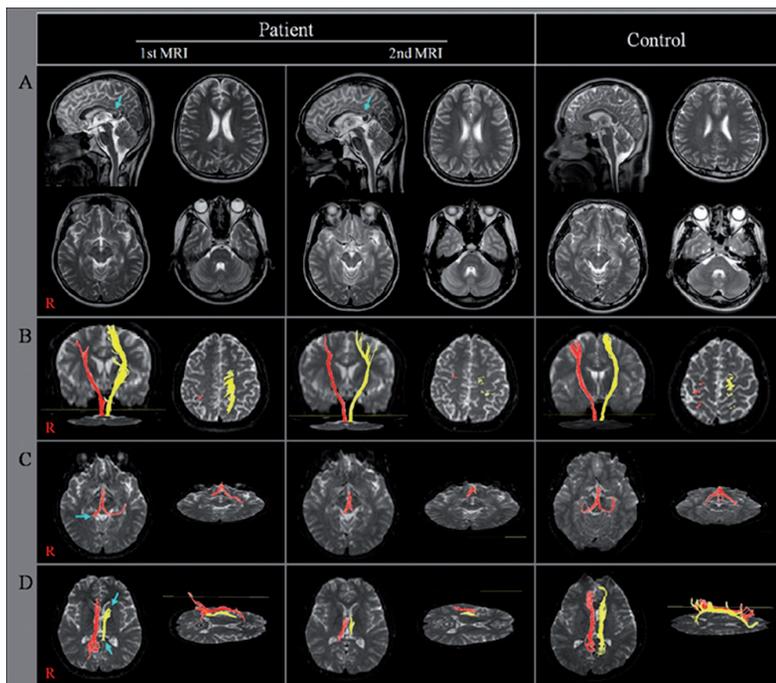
T2-weighted magnetic resonance images taken 3 months after onset showed an encephalomalactic lesion (arrow) in the posterior portion of the corpus callosum (A). The integrity of (B) both corticospinal tracts (CST), (C) left fornix, and (D) right cingulum were preserved on the first diffusion tensor tractography (DTT); however, compared with controls, there were interruptions in both ends of the left cingulum (arrow) and right fornical crus (arrow). On the second DTTs, both the cingulum and fornix showed severe degeneration, although the integrities of both CST were well preserved.
